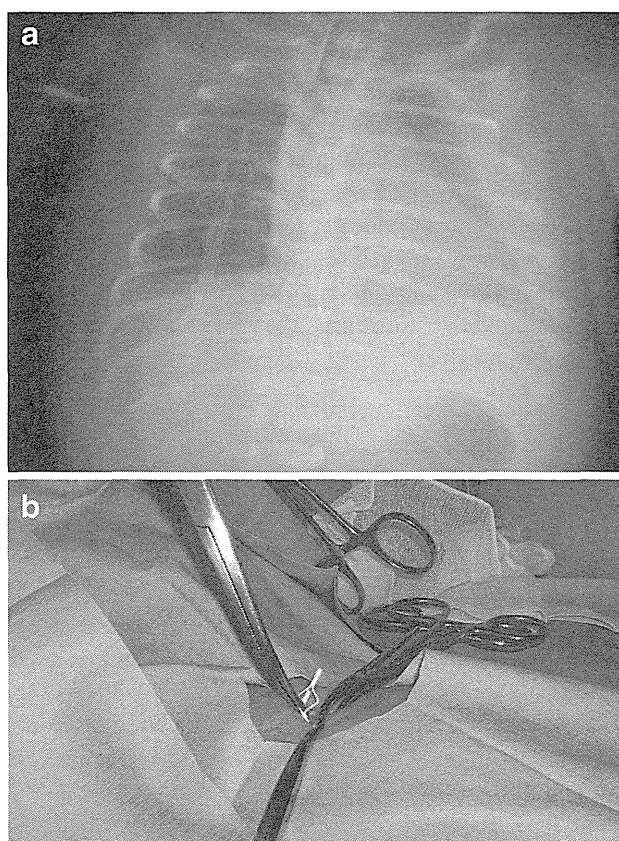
Case 1: chest X-ray after aspiration of the right pleural effusion (a) and photograph of a surgically removed dislodged thoracoamniotic shunt catheter (b). Two dislodged shunt catheters in the right thorax were detected by chest radiography. Right pleural effusion was completely aspirated 2-h after delivery (a). The catheters were removed safely through a small surgical incision (b)
